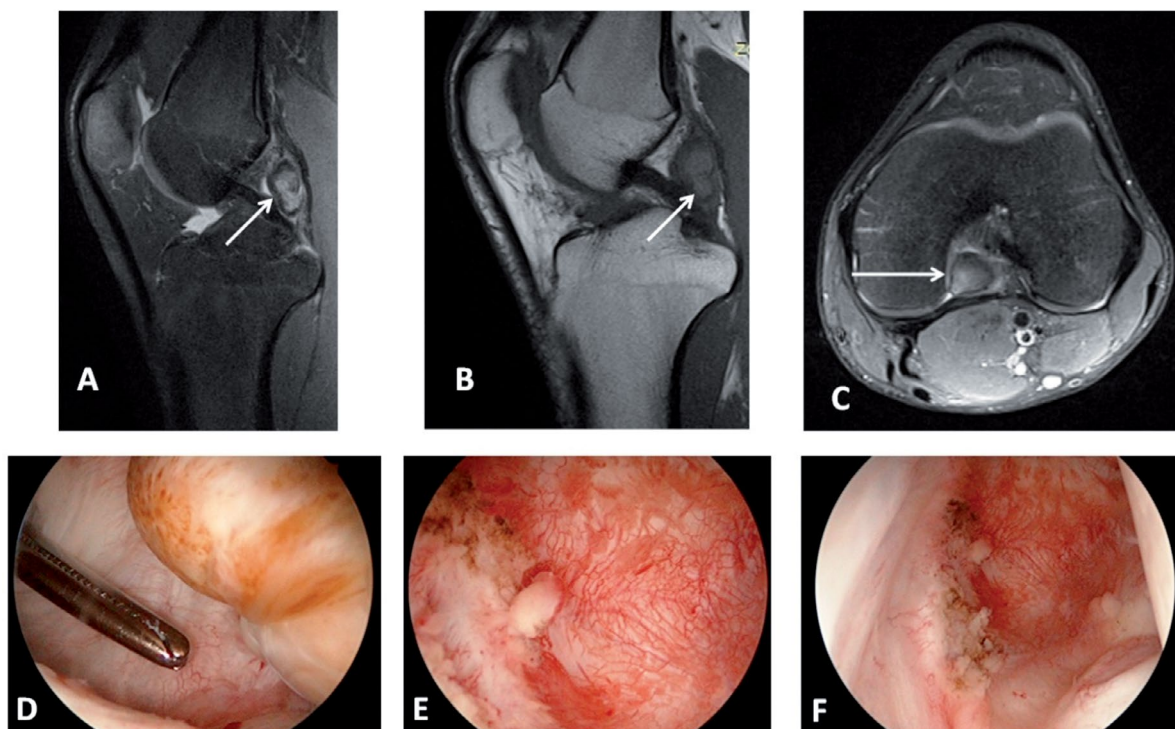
Case 9, a 17-year-old male patient: (A) sagittal view on magnetic resonance image (MRI) with PD-FS technique with the arrow pointing at the well-defined, lobulated isointense lesion localized in the medial posterior compartment of the knee; (B) sagittal view on MRI with T1-FS technique with the arrow pointing at the well-defined, lobulated isointense lesion localized in the medial posterior compartment of the knee; (C) axial view on MRI with PD-FS technique with the arrow pointing at the well-defined, lobulated isointense lesion localized in the medial posterior compartment of the knee; (D) arthroscopic view from the anterolateral portal showing a nodule of pigmented villonodular synovitis posteriorly to the posterior horn of the medial meniscus. The instrument is placed into the knee through the posteromedial portal; (E) arthroscopic view from the posteromedial portal showing the area around the base of the nodule; (F) arthroscopic view from the posteromedial portal after partial synovectomy of the area surrounding the base of the lesion.
